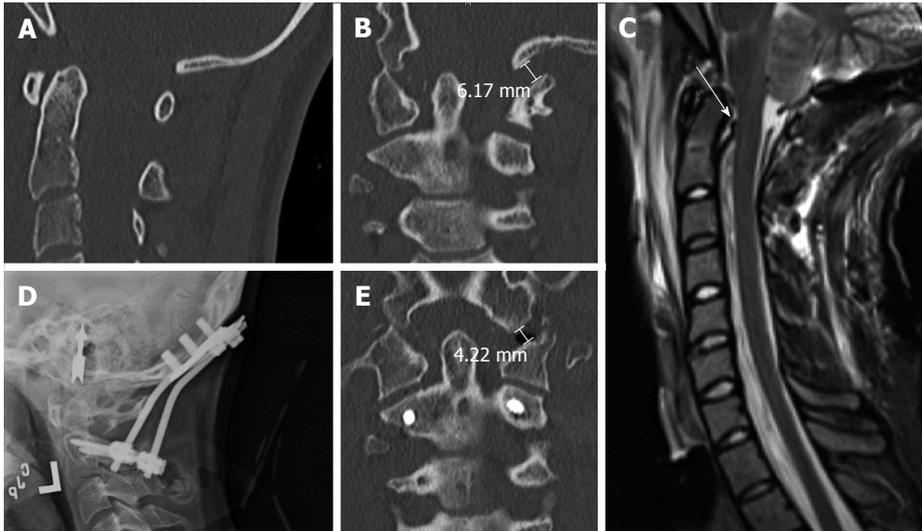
Nineteen years old woman with traumatic atlanto-occipital dislocation following high-speed motor vehicle accident. A and B: CT of the cervical spine demonstrates no significant abnormalities in the midsagittal plane (A), but clear asymmetry of the occipito-atlantal joints in the coronal plane (B). The left occipital condyle-C1 interval is increased, measuring 6 mm; C: MRI of the cervical spine (T2WI) reveals abnormal signal suggesting disruption of the cruciate ligament; D: Post-operative cervical radiographs show O-C2 fusion using bicortical occipital screws and C2 pedicle screws; E: Post-operative CT of the cervical spine demonstrates reduction of the left occipital condyle-C1 interval to 4 mm. CT: Computed tomography; MRI: Magnetic resonance imaging.
